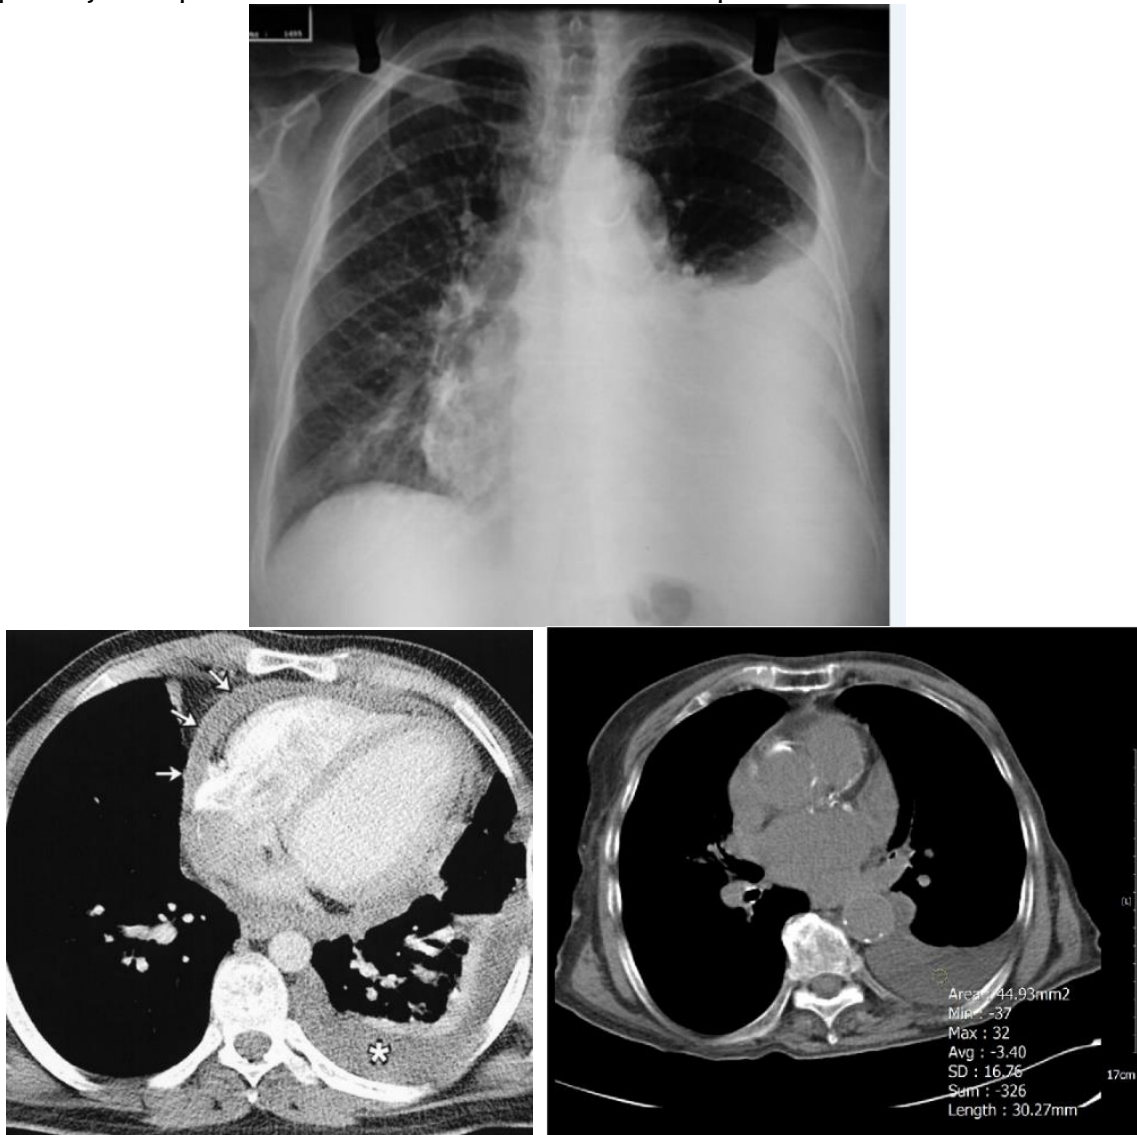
(a) Chest x-ray shows left-sided pleural effusion, (b) Chest tomography shows left-sided pleural effusion and pericardial effusion.
